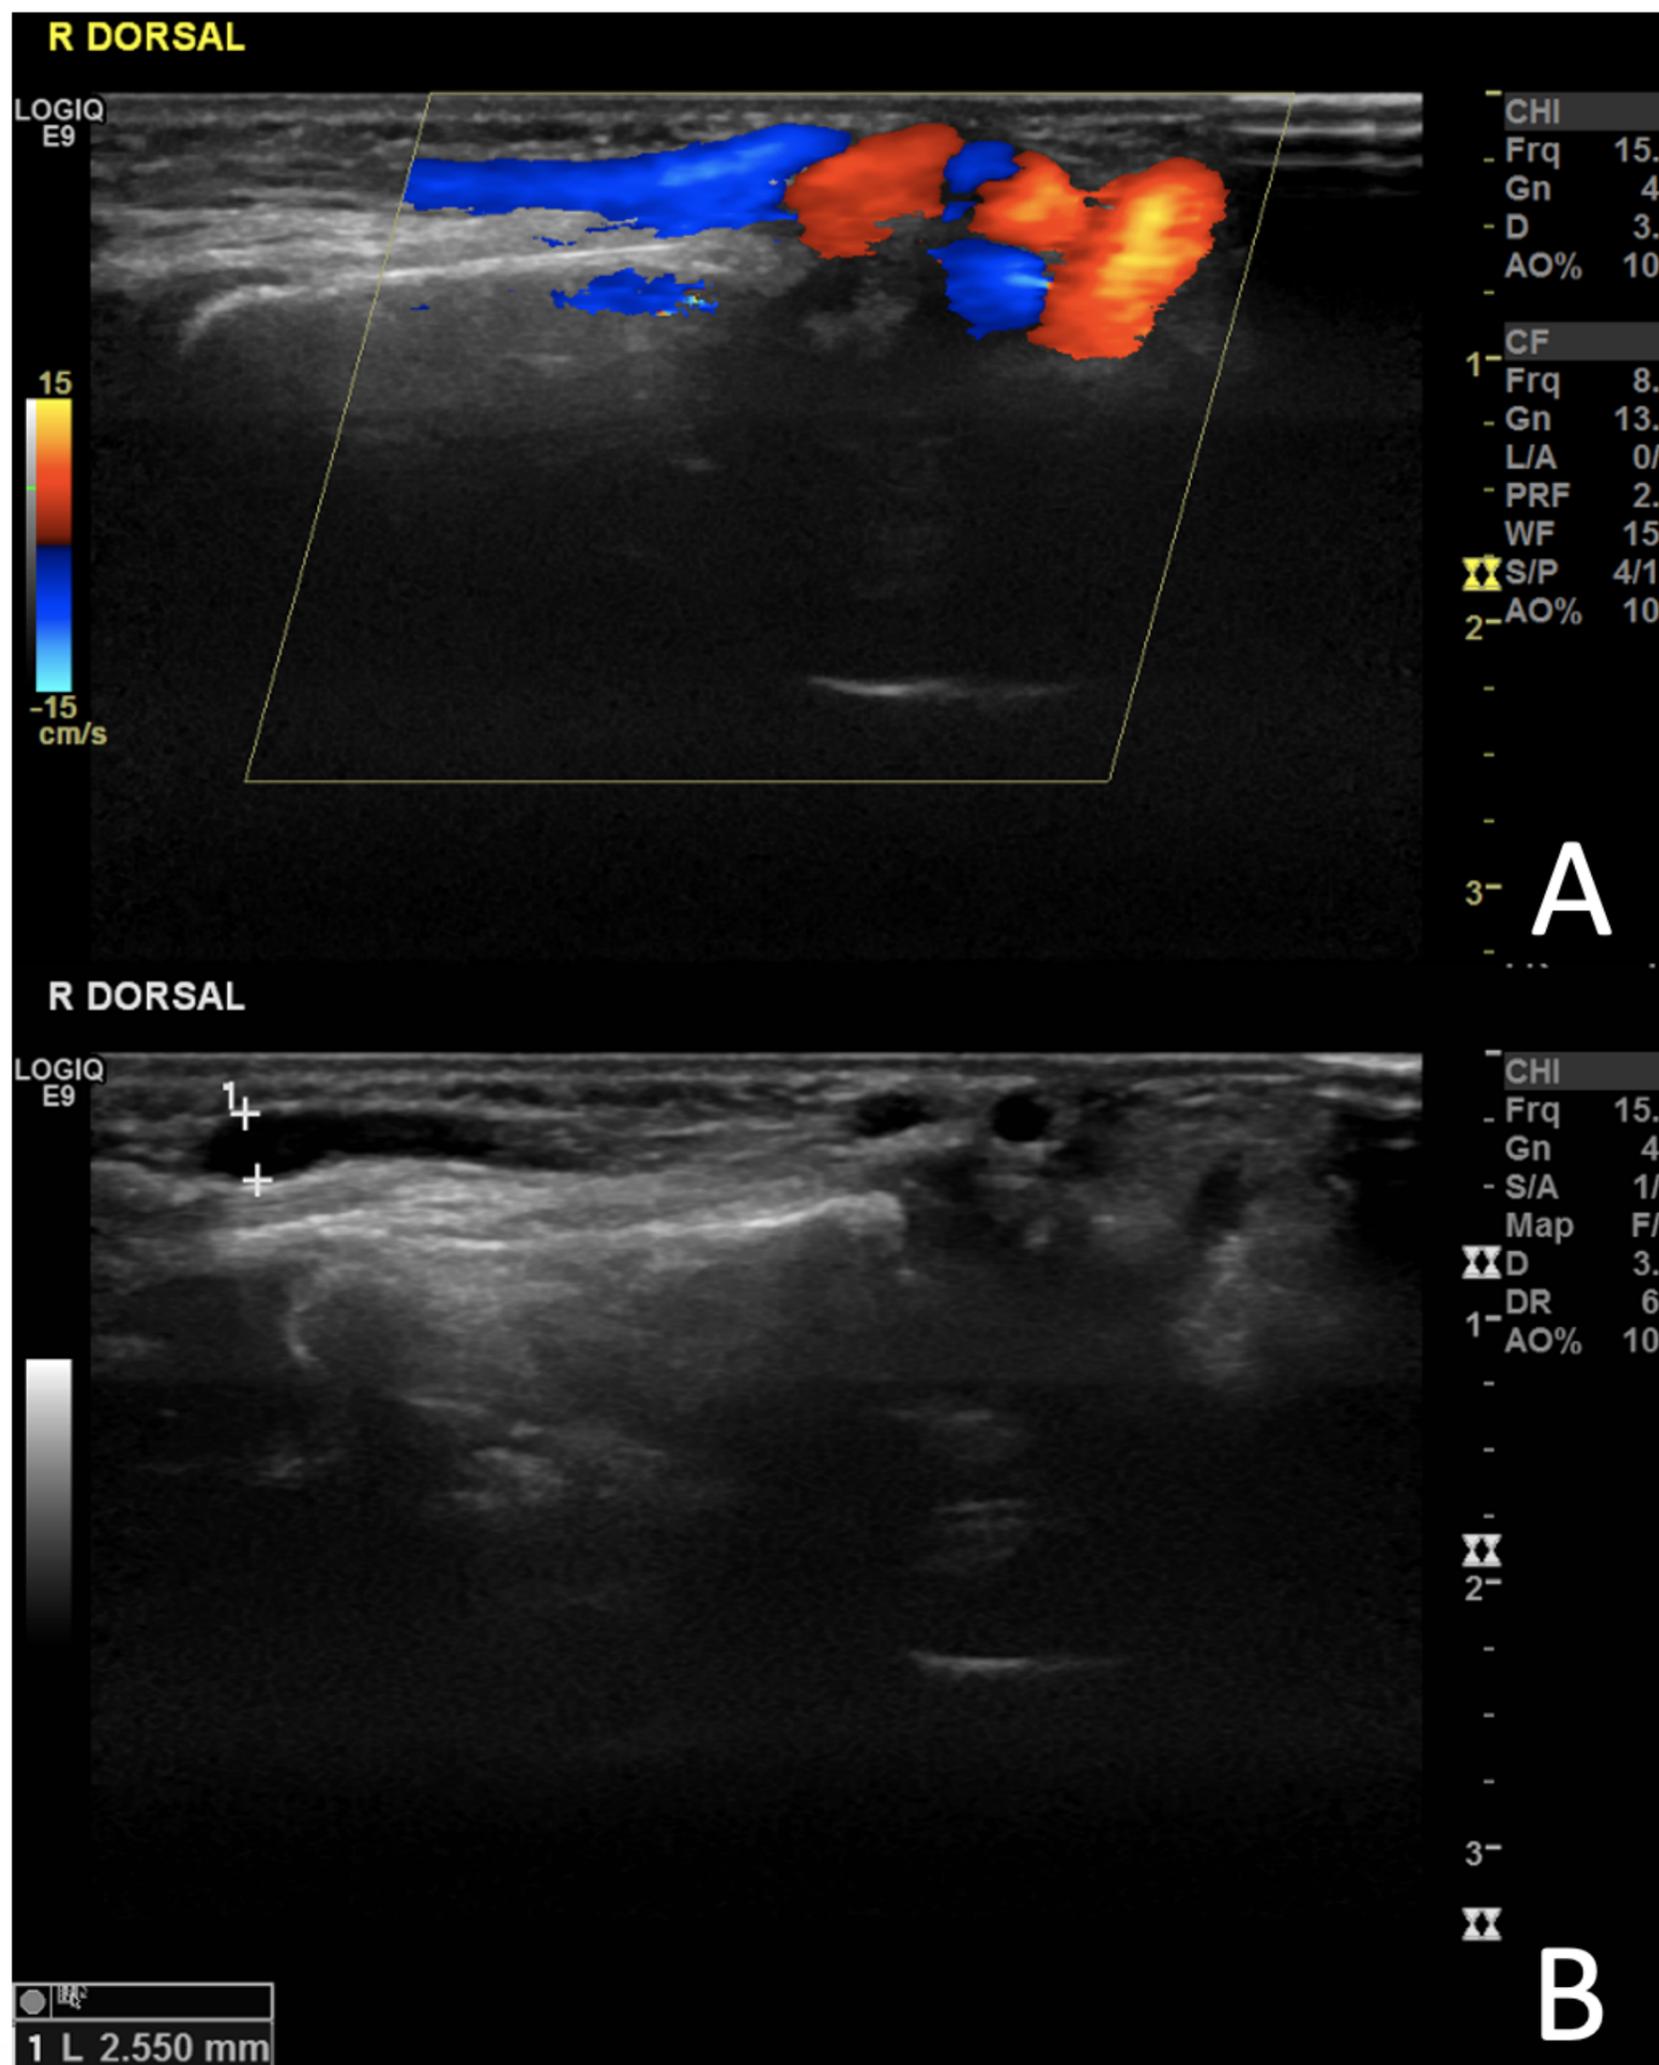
(A) Color Doppler showing the characteristic yin-yang flow within the arteriovenous fistula. (B) The artery was markedly enlarged with an internal diameter of 2.55 mm.
